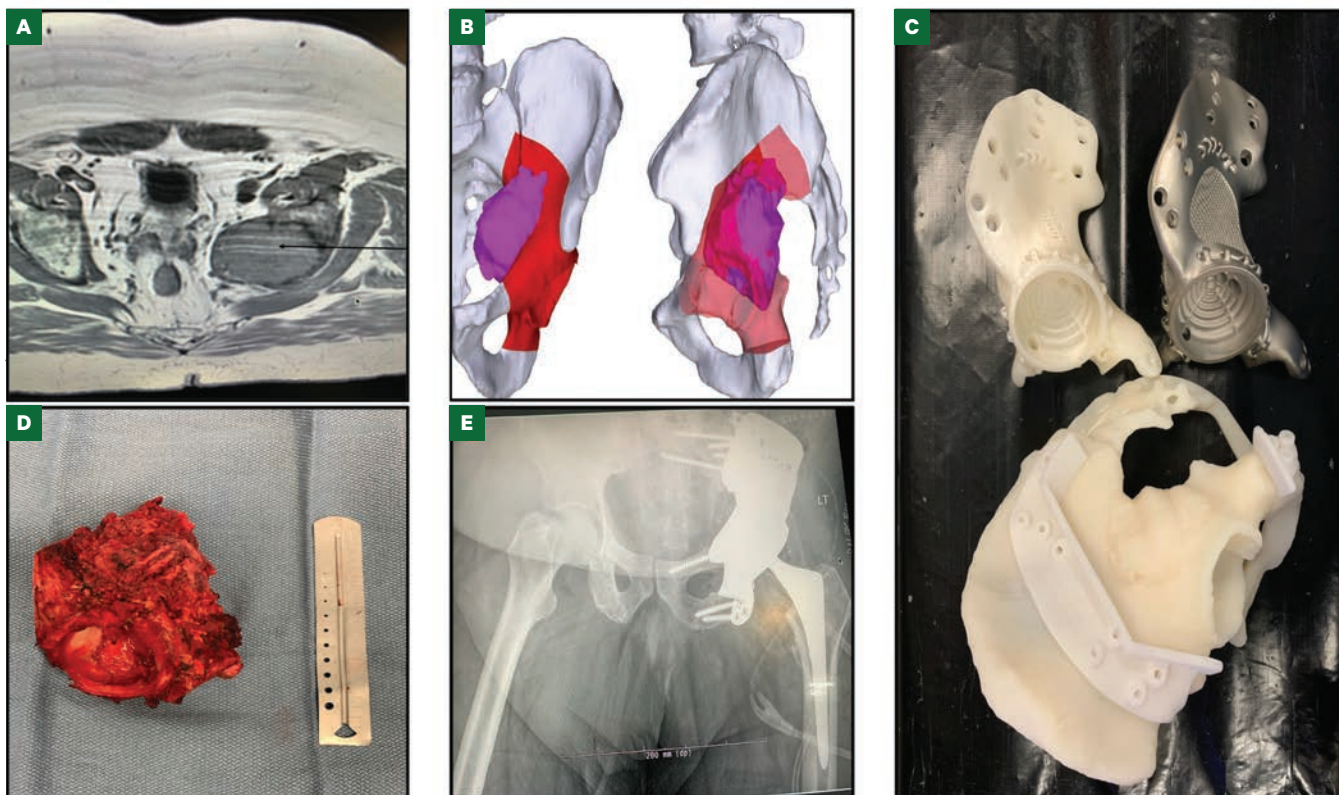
Images from an Internal Hemipelvectomy and Reconstruction of Acetabulum in a 54-Year-Old Male, Using a 3-Dimensional (3D)-Printed Implant. A, Axial T1-weighted magnetic resonance image showing a large, left-sided acetabular destructive lesion consistent with a solitary site of renal cell carcinoma (black arrow). B, 3D reconstructions of the large pelvic malignancy generated using computed tomography and magnetic resonance imaging from a planning session with computer engineers and surgeon. The teams used these images to define the sites of resection and the reconstructive approach. Purple is the malignancy, and red is the planned resection with negative margin. C, Photograph showing the 3D-printed cutting guide and 3D-printed implant used in reconstruction of the acetabulum after removal of the destructive lesion. D, Intraoperative photograph of the resected acetabular mass reconstructed with the 3D-printed acetabular implant. E, Anteroposterior radiograph of pelvis showing final status.
